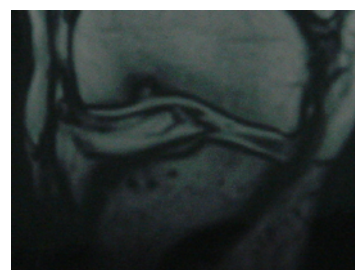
Sagittal MRI for 42 years old male with 4 years history of right knee pain showing osteochondral defect about 3 cm<sup>2</sup> of medial femoral condyle.
